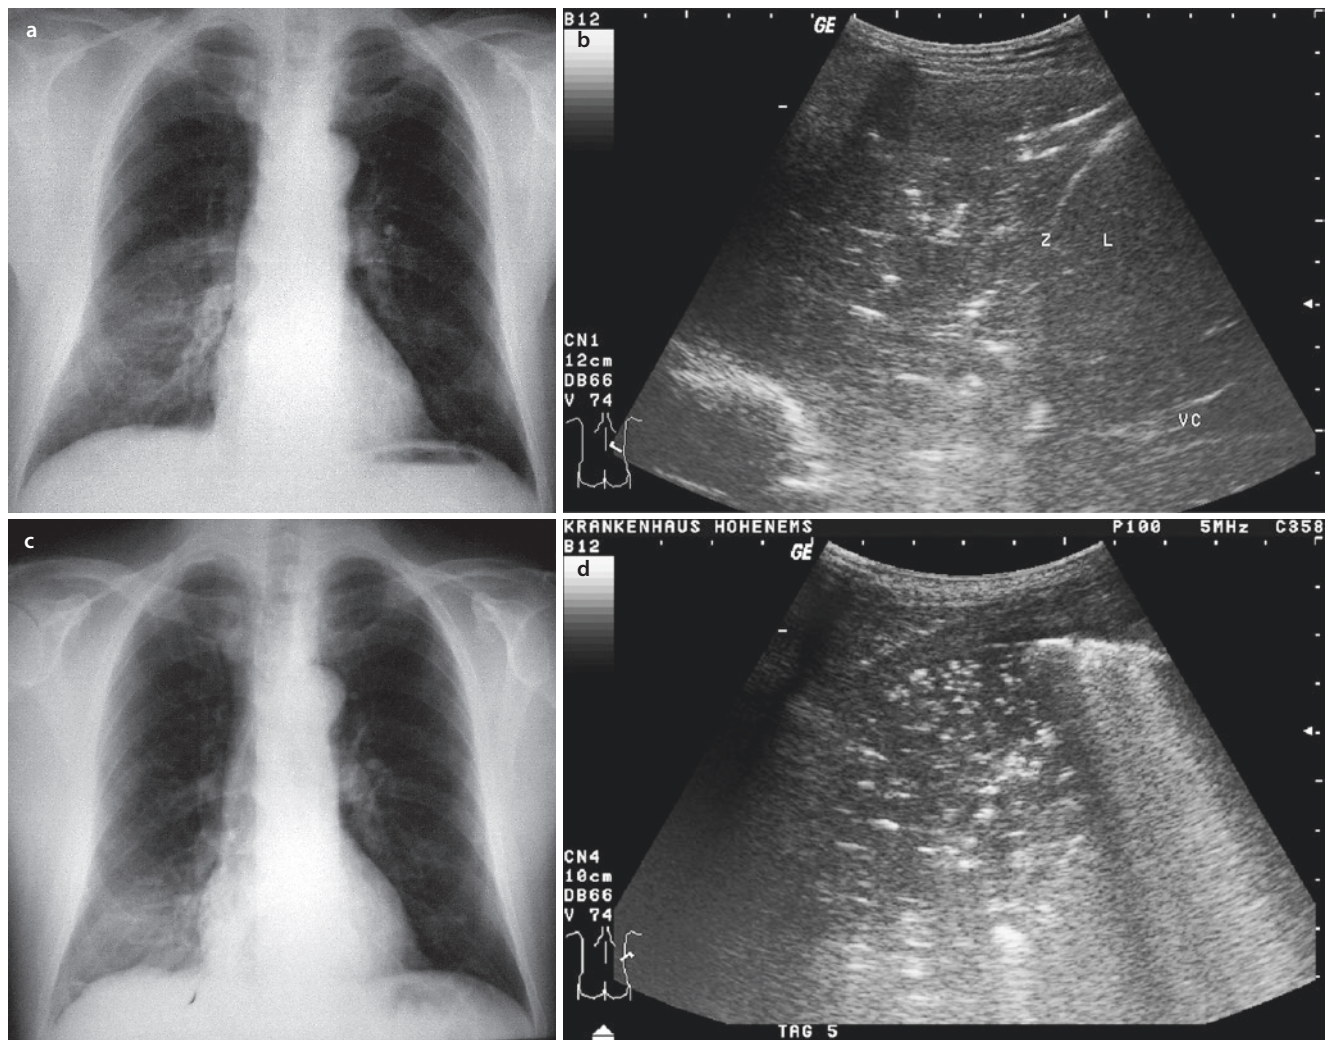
A 72-year-old man with clinically severe pneumonia. a Typical appearance on X-ray. b On sonography the echotexture is similar to that of the liver, with a pronounced bronchoaerogram. Z diaphragm, L liver, VC vena cava. After 1 week of antibiotic therapy
